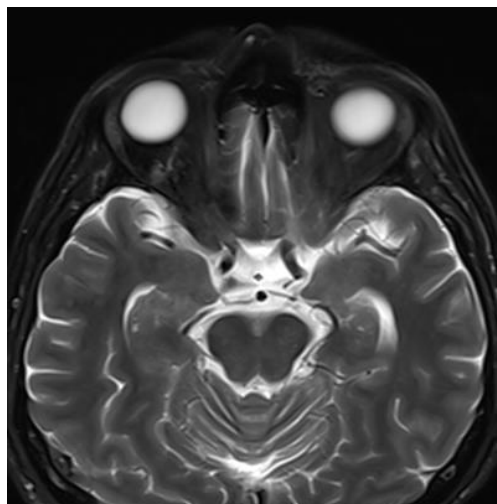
Cavernous angioma of the right eye socket on MRI tomogram
